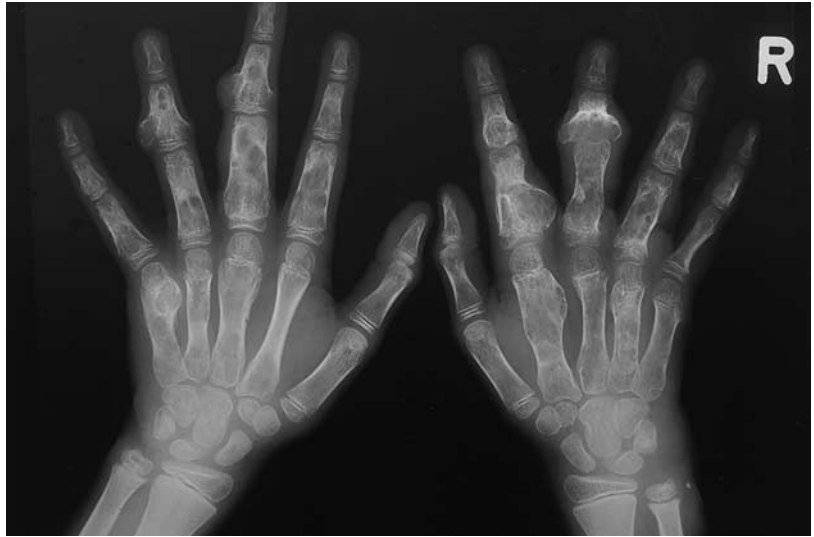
Frontal (a) and oblique (b) radiographs of the hands obtained at the age of 18 years show the typical ring-and-arc appearance of chondroid lesions in the matrix of the osseous lesions. The well-defined round calcifications in the soft-tissue masses are typical of phleboliths.
